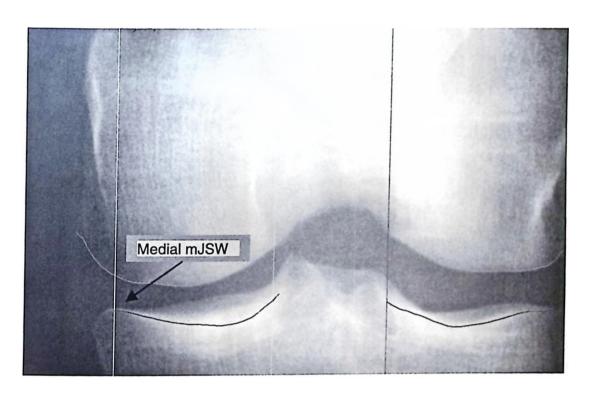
Analysis of a digitized radiograph using the automated software algorithm. The algorithm delineates the medial (left) and lateral (right) compartments of the knee, the femoral condyles and the tibial plateau. The red lines indicated the mJSW in the medial and lateral compartments.
